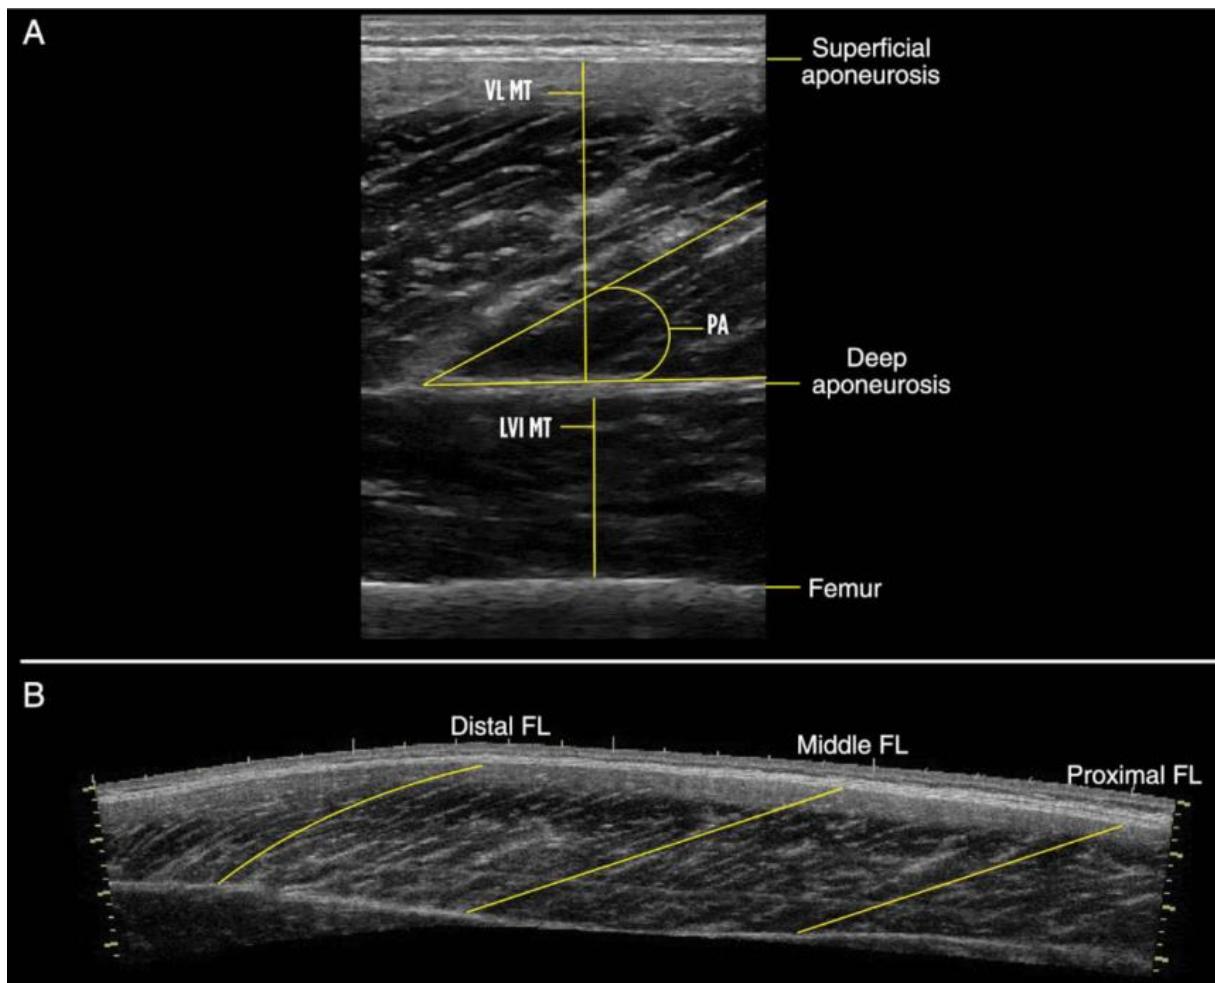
(A) B-mode ultrasound image of the mid VL and LVI. (B) Extended field-of-view image of the VL. VL = vastus lateralis; LVI = lateral vastus intermedius; MT = muscle thickness; PA = pennation angle; FL = fascicle length.
